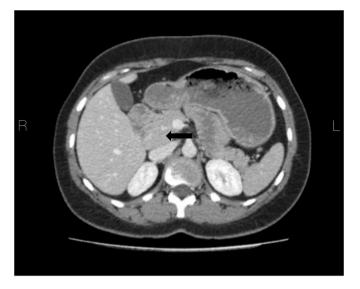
CT scan showed an enhanced mass on retroperitoneum back of pancreas without any invasion.
